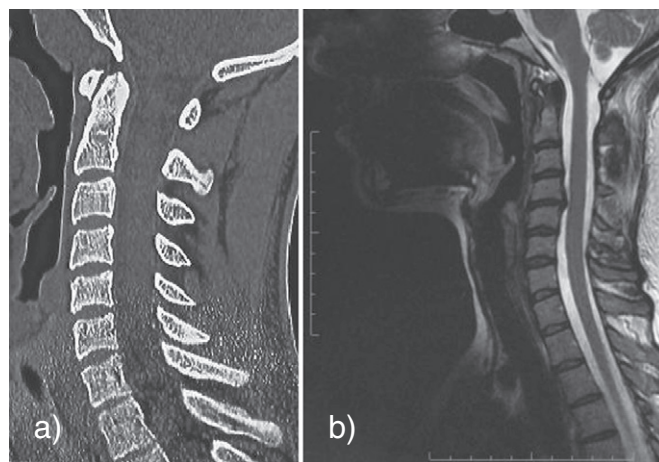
Images: a) CT of intact cervical spine – base for geometrical model FE b) MRI cervical spine with C4C5 intervertebral herniation.
